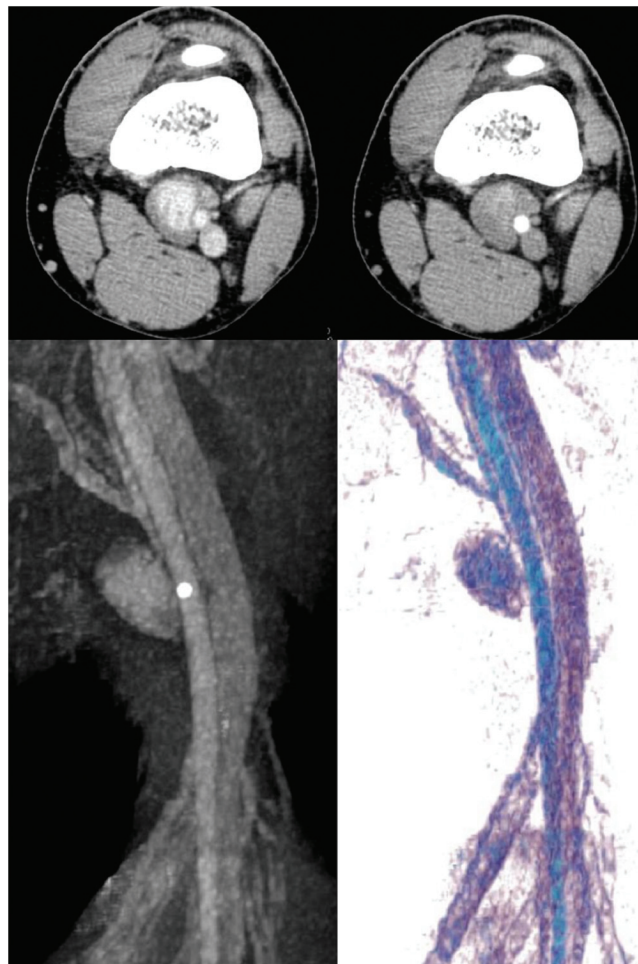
Angio-computed tomography (ACT) acquisition confirmed a 36×17 mm oval mass in the left popliteal fossa and appeared to be a true venous aneurysm; scan reconstruction using maximal intensity projection and volume rendering technique showing the popliteal venous aneurysm.
